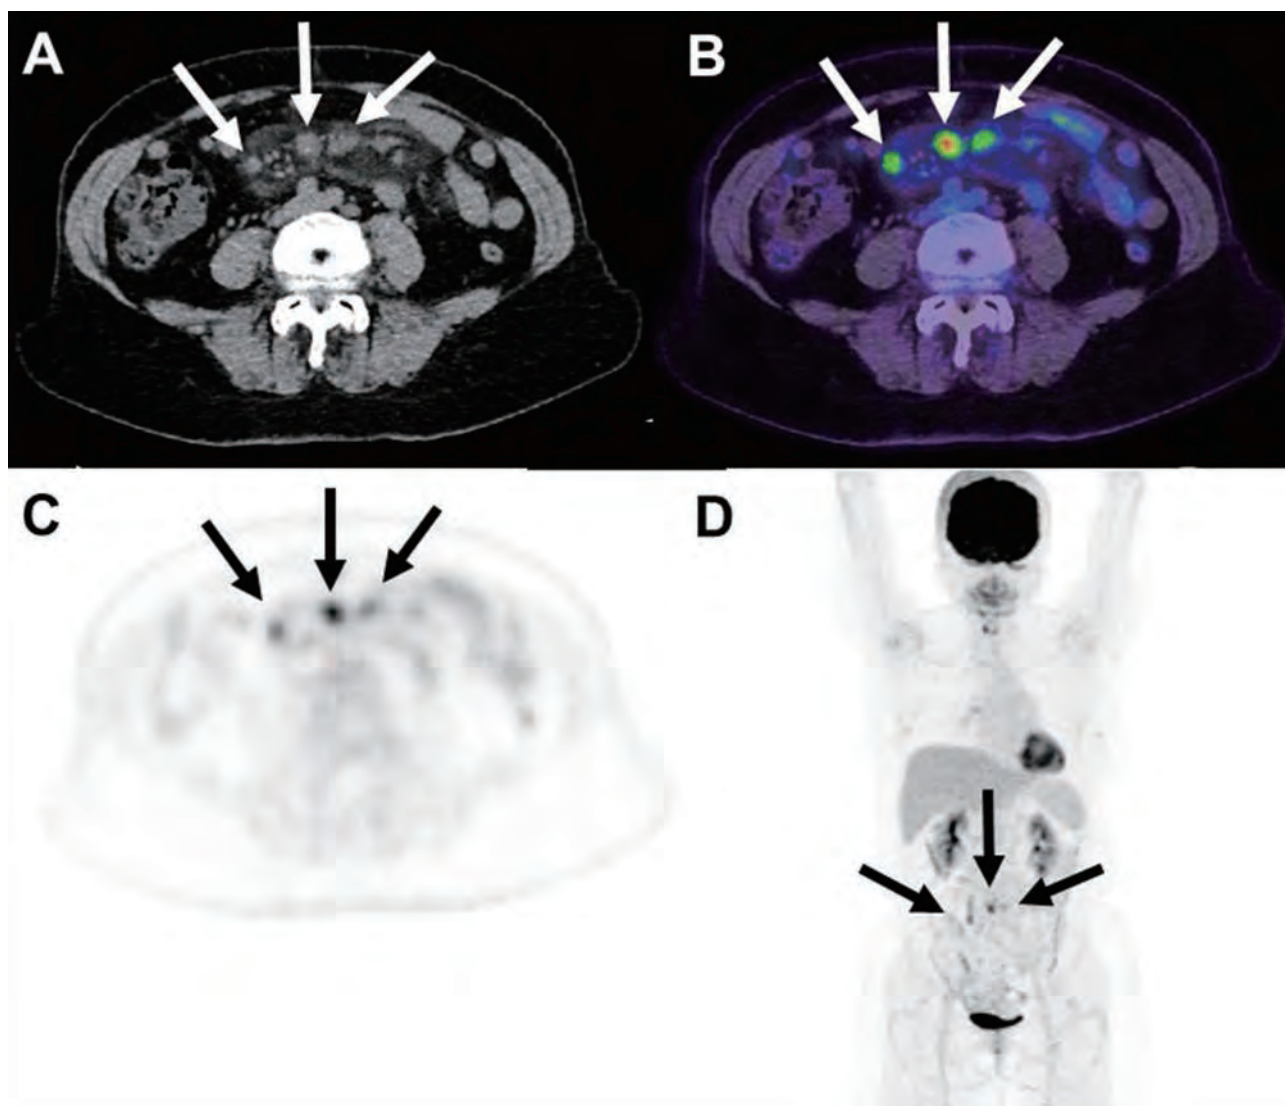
A 58-year-old woman had history of the abdominal discomfort and anal pain for one month. She is referred for FDG PET/CT to evaluate the extent of the disease. The arrow pointed to ill-defined nodular lesions (the largest size 2 cm) (A, Transverse CT; B, Transverse PET/CT fusion) and mesenteric fatty stranding with increased FDG uptake (C, Transverse PET; D, MIP images of PET) in the mid abdominal cavity.
